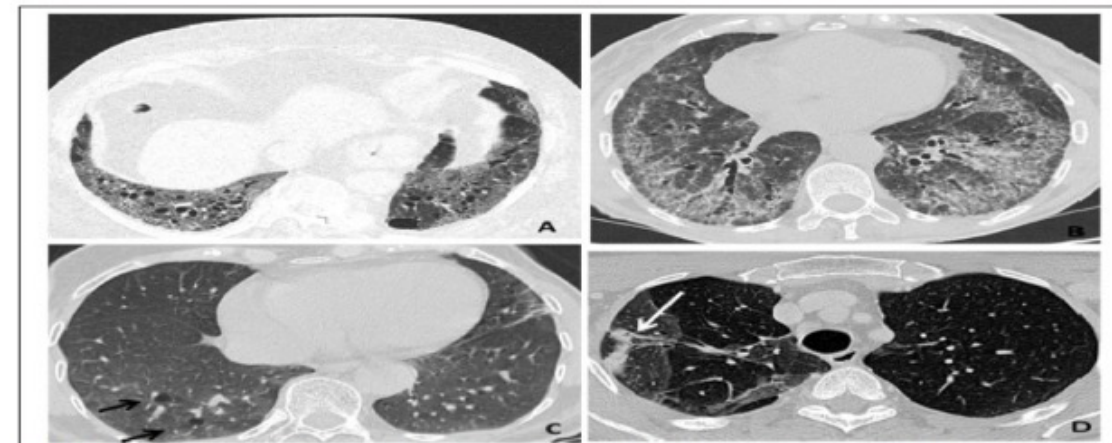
High-resolution computed tomography (HRCT) findings in respiratory diseases and particularly interstitial disease (IA). (A) An usual interstitial pneumonia (UIP) pattern representing the most typical radiological presentation in patients with IVD is primarily characterized by reticular markings, traction bronchiectasis, and subpleural cysts (honeycombing). (B) A nonspecific interstitial pneumonia (NSIP) pattern is primarily characterized by ground-glass opacities, variably mixed with reticular thickening, and tubular bronchiectasis (black arrows). (C) A lymphocytic interstitial pneumonia (LIP) pattern is primarily characterized by peribronchovascular thickening (black arrows). (D) An organizing pneumonia (OP) pattern is primarily characterized by pulmonary consolidation (white arrow).
